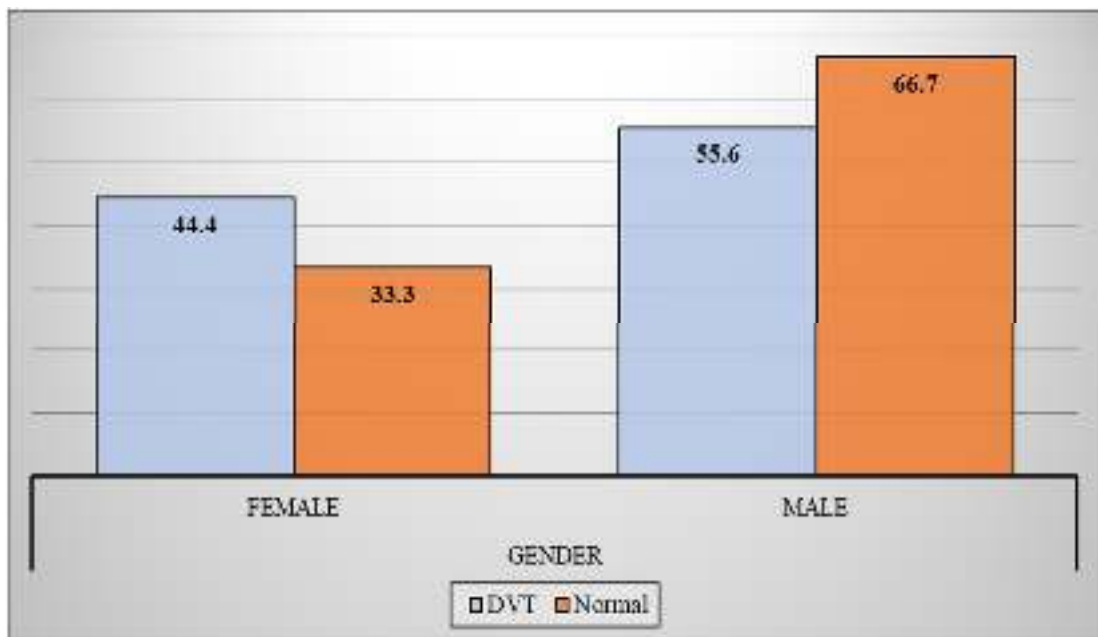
Distribution of subjects by gender and post-operative Doppler study.
